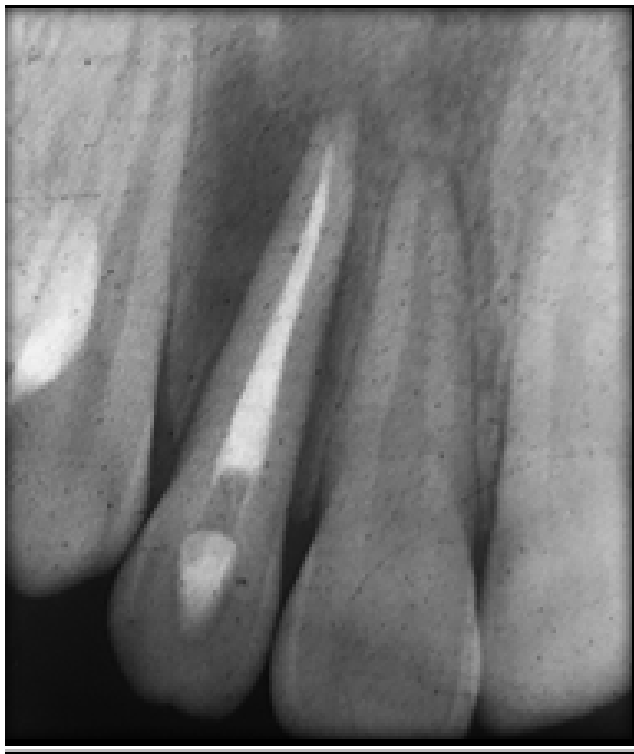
Immediate post op radiograph
